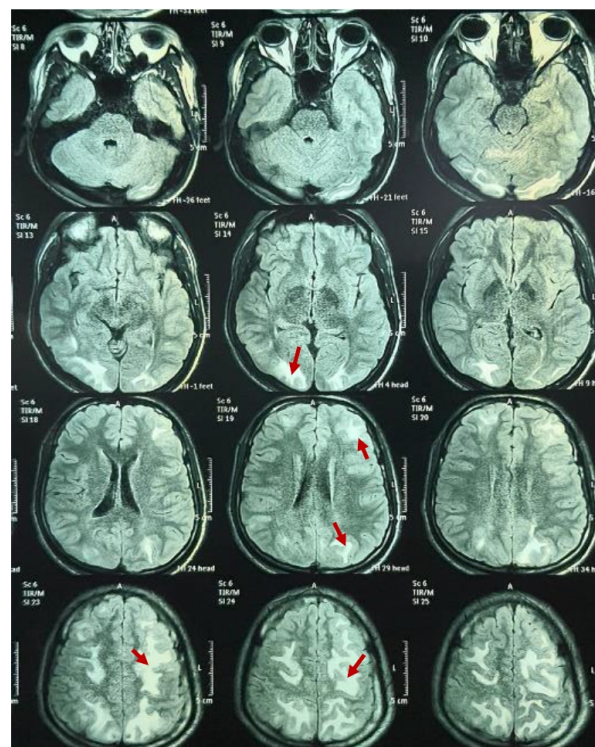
FLAIR (Fluid alternated inversion recovery) image of MRI brain showing frontal-parieto-occipital white matter abnormalities (red arrows)
